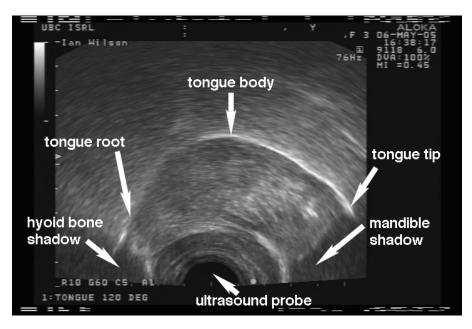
A midsagittal ultrasound image of the tongue (prominent white line = tongue surface)
